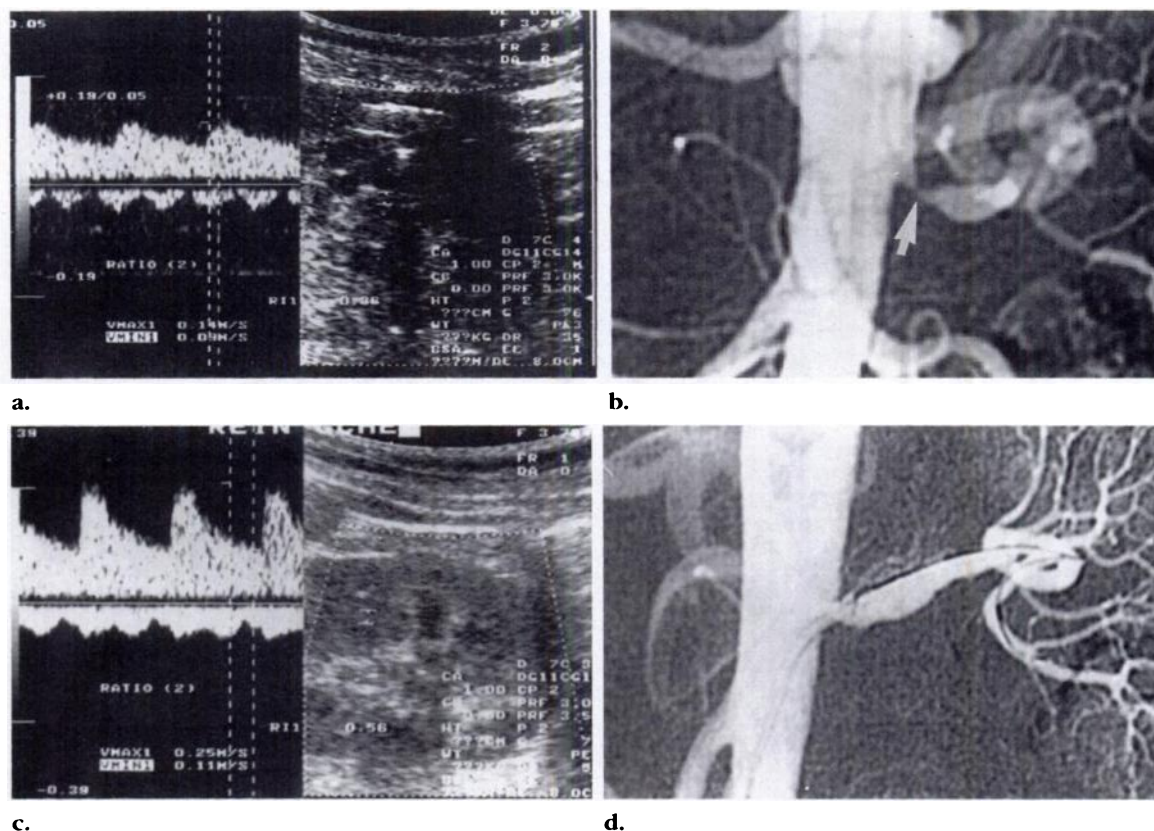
Severe stenosis with downstream repercussions. (a) Doppler spectrum (left) and sonogram (right) of the interlobar arteries show a tardus-parvus waveform due to downstream repercussions induced by a severe stenosis of the left RA. (b) Angiogram shows the severe stenosis of the left RA (arrow). (c) Doppler spectrum (left) and sonogram (right) obtained after balloon angioplasty of the left RA show improvement in distal renal arterial flow with normal systolic velocities. (d) Postangioplasty arteriogram shows improvement of the stenosis.
